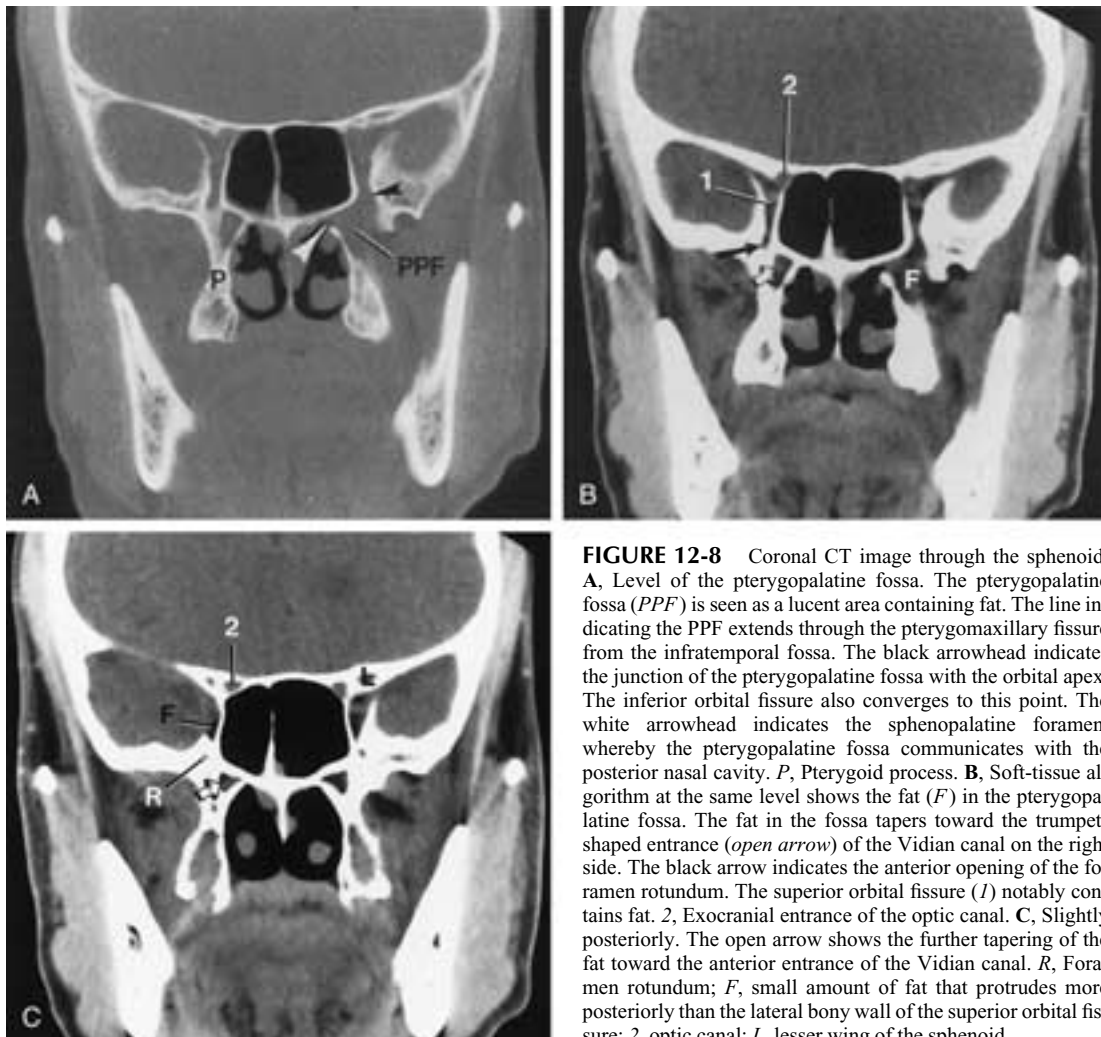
Coronal CT image through the sphenoid. A, Level of the pterygopalatine fossa. The pterygopalatine fossa (PPF) is seen as a lucent area containing fat. The line indicating the PPF extends through the pterygomaxillary fissure from the infratemporal fossa. The black arrowhead indicates the junction of the pterygopalatine fossa with the orbital apex. The inferior orbital fissure also converges to this point. The white arrowhead indicates the sphenopalatine foramen, whereby the pterygopalatine fossa communicates with the posterior nasal cavity. P, Pterygoid process. B, Soft-tissue algorithm at the same level shows the fat (*F*) in the pterygopalatine fossa. The fat in the fossa tapers toward the trumpet-shaped entrance (*open arrow*) of the Vidian canal on the right side. The black arrow indicates the anterior opening of the foramen rotundum. The superior orbital fissure (*1*) notably contains fat. 2, Exocranial entrance of the optic canal. C, Slightly posteriorly. The open arrow shows the further tapering of the fat toward the anterior entrance of the Vidian canal. R, Foramen rotundum; F, small amount of fat that protrudes more posteriorly than the lateral bony wall of the superior orbital fissure; 2, optic canal; L, lesser wing of the sphenoid.
